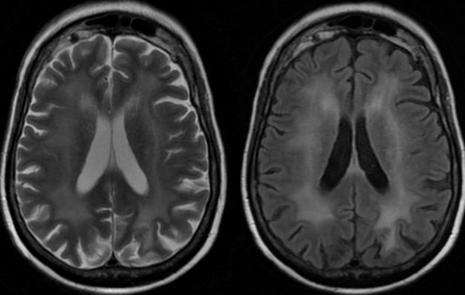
Radiation-induced leukoencephalopathy in a 70-year-old woman who received whole-brain radiation therapy (RT) for brain metastasis related to breast cancer. Axial T2-weighted and FLAIR images before (a and b) and 18 months (c and d) after treatment show the onset of symmetric and diffuse white matter hyperintensity and atrophy (c and d).
